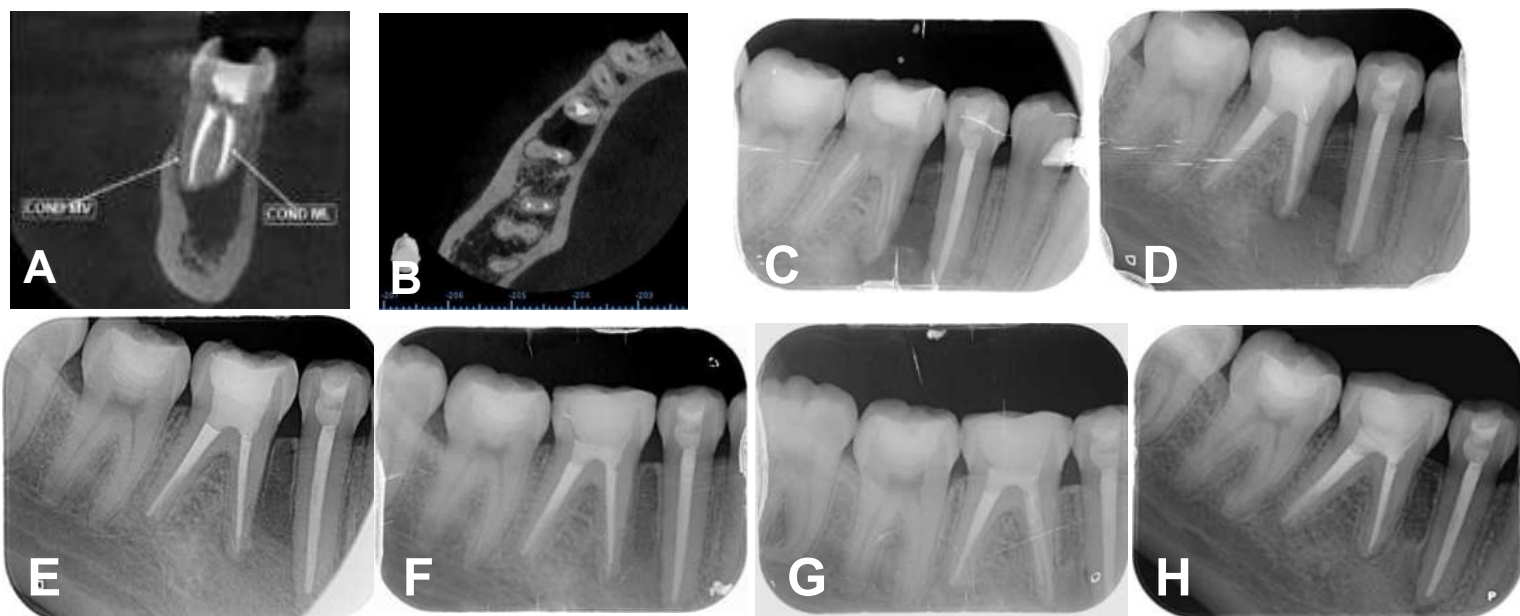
A) and B) Pre-treatment CBCT slices, C) Pre-treatment radiograph, D) Immediate post-obturation control, E) 30-day follow-up, F) 3-month follow-up, G) 12-month follow-up H) 24-month follow-up.
